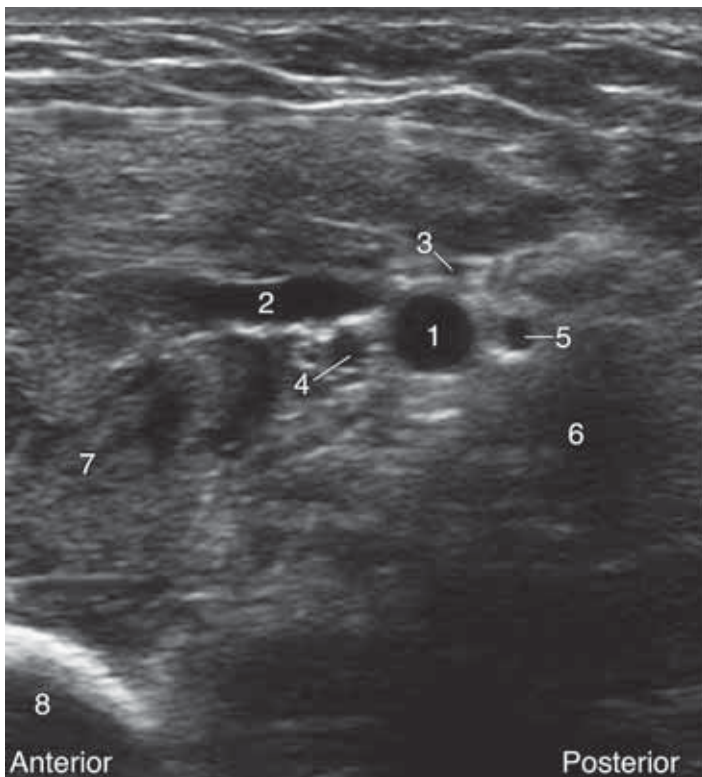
Ultrasound image of axillary area. 1 = Axillary artery; 2 = Axillary vein; 3 = Ulnar nerve; 4 = Median nerve; 5 = Radial nerve; 6 = Triceps brachii muscle; 7 = Coracobrachialis muscle; 8 = Humerus.
